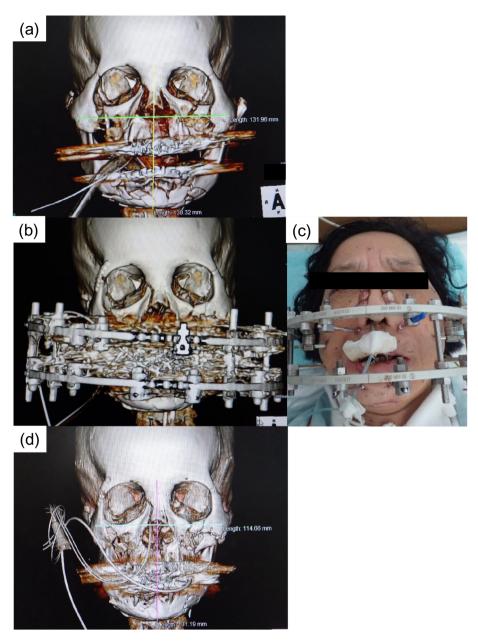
Preoperative head three-dimensional computed tomography (3DCT) (a) showed dilated bilateral zygoma. Postoperative head 3DCT scans (b) and frontal appearance (c) are shown. Postoperative head 3DCT which was performed after the removal of the Ilizarov-type external fixator (d) showed that the facial width had decreased while its length had increased.
